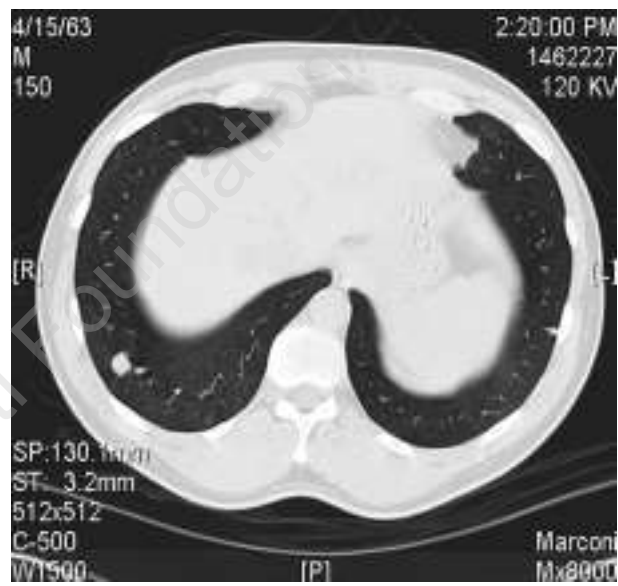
Pulmonary AVM by chest CT.
